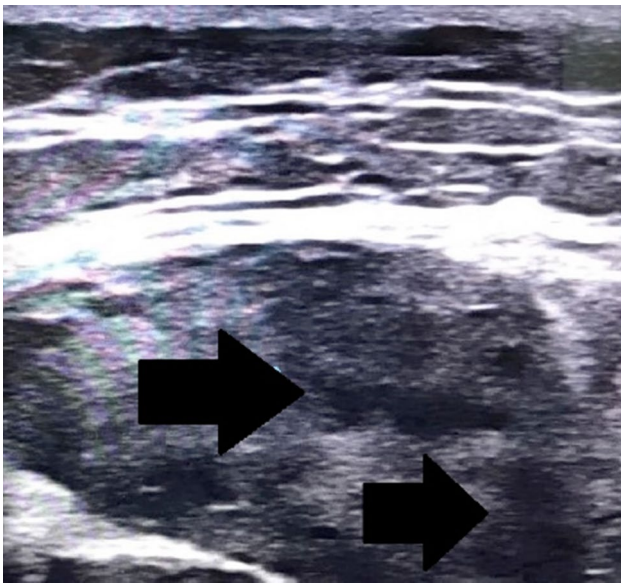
A preoperative ultrasonographic image of mass lesion.
